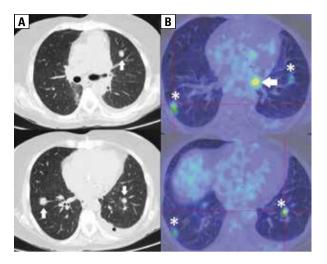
A. Computed tomography axial view showing multiple pulmonary nodules (white arrows) associated with left pleural effusion (black asterisk). A total of 13 nodules were detected, 8 in the right lung and 5 in the left lung; B. ¹⁸F-Fluoro-Deoxy-Glucose positron emission tomography detecting an increased uptake in the pulmonary nodules (white asterisks) and mediastinal lymph nodes (white arrow). No pleural uptake was detected
